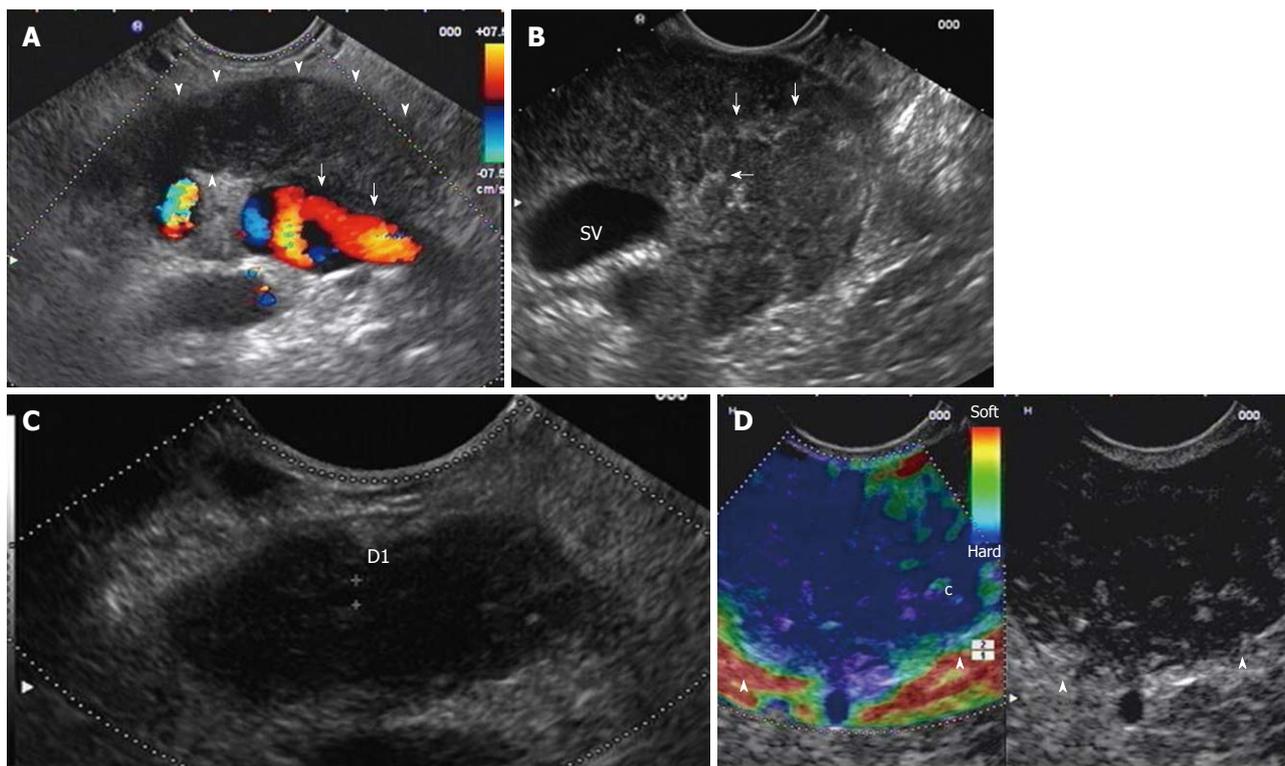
Diffuse form of autoimmune pancreatitis. A: Endoscopic ultrasonography (EUS) linear scanning shows a diffuse pancreatic enlargement (arrowheads) with echopoor echotexture, and with loss of interface with splenic vein (arrows); B: Parenchymal lobularity and hyperechoic strands (arrows) are visible in the enlarged gland; C: Pancreatic duct calliper is 1.8 mm; D: EUS-elastography demonstrates the diffuse pancreatic stiffness (arrowheads).
